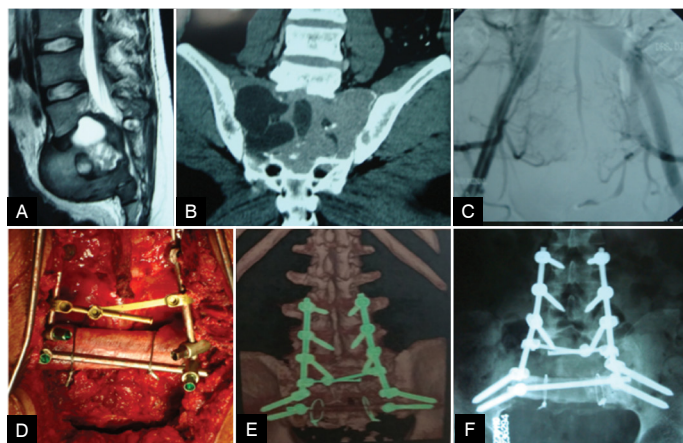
30-year-old male with sacral GTC undergoing intralesional resection and spinopelvic reconstruction. A- Sagittal MRI showing anterior tumor mass in the pelvis, B- Coronal CT scan showing extensive involvement of the sacrum, C- Arteriography and CT embolization, D- Intraoperative image of reconstruction with bone allograft, E and F- Postoperative CT and radiography images.
